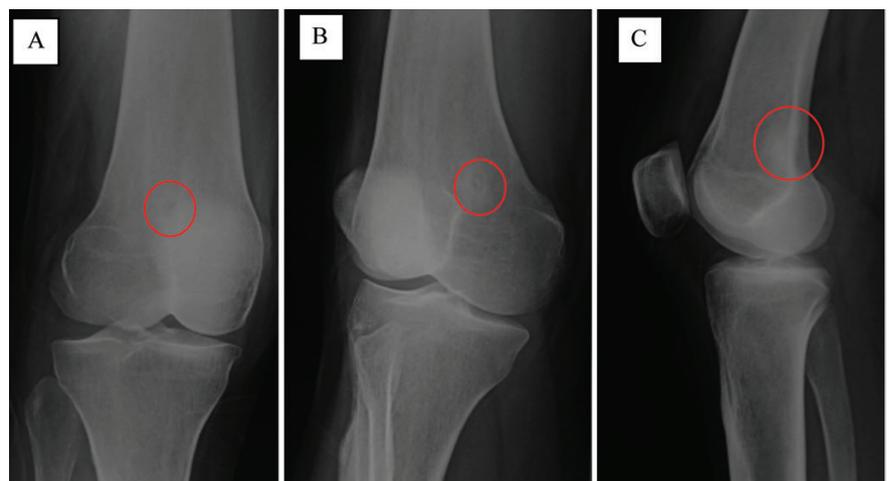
Anteroposterior (A), 3/4 (B), and lateral (C) radiographs of the periosteal osteoid osteoma of the distal femur.
